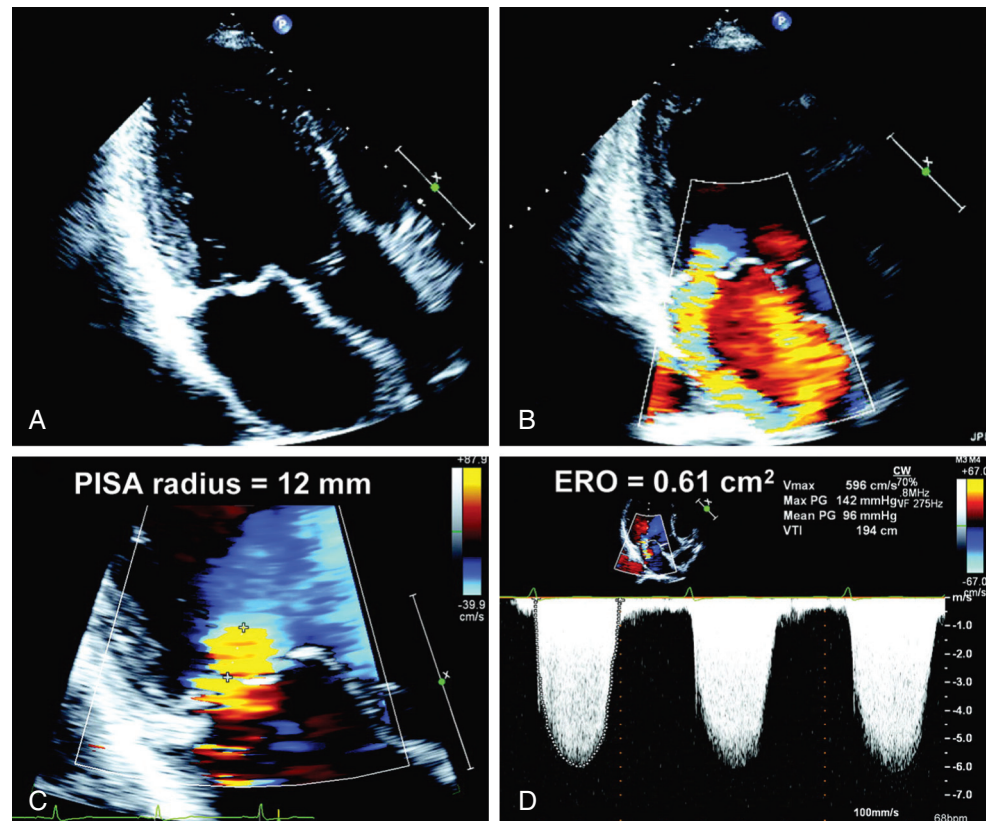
Severe MR caused by prolapse of the mitral valve with quantitative determination of effective regurgitant orifice area (ERO) on echocardiography. A, B, Severe prolapse of the mitral valve with severe MR was observed. C, D, ERO was calculated with the PISA radius and peak velocity of the MR jet. (From Kang DH, Kim JH, Rim JH, et al: Comparison of early surgery versus conventional treatment in asymptomatic severe mitral regurgitation. *Circulation* 119:797, 2009.)
